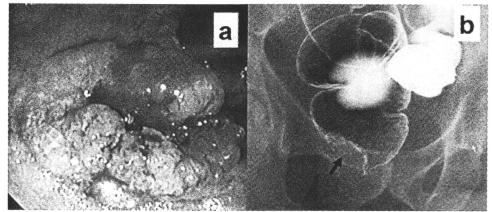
Local recurrence 29 months after endoscopic mucosal resection. (a) Colonofiberscopy showed an elevated lesion with an ulcer. (b) A shadow defect could be seen in the lower rectum in a double-contrast roentgenogram.
